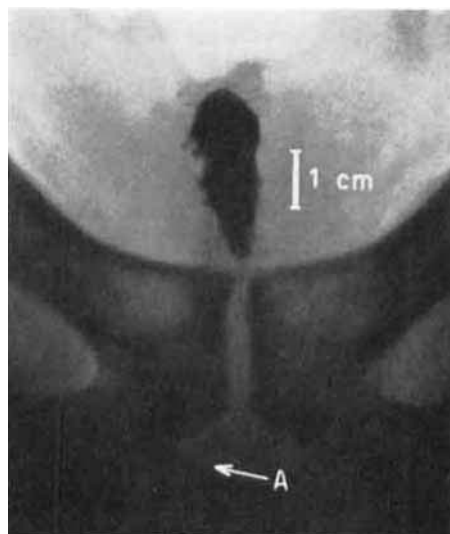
Roentgenograph of the pelvic inlet of 34-year-old man, in the supine position, 5 minutes after insertion of a type A suppository. The suppository has completely disintegrated. Arrow *A* marks the position of the anal orifice, to which in this and in the following figures, a lead strip piece was juxtaposed. The dimension of 1 cm. on the plane of the suppository is also marked. The size and shape of the suppository were the same as in Fig. 2.
